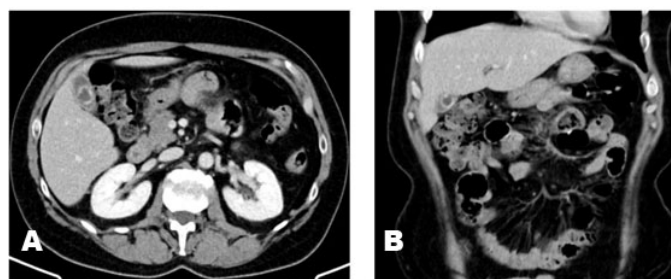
(A) Coronal and (B) axial slices of the preoperative CT of the abdomen performed in a 56F (Case 1) demonstrating a large gallstone within the gallbladder.
